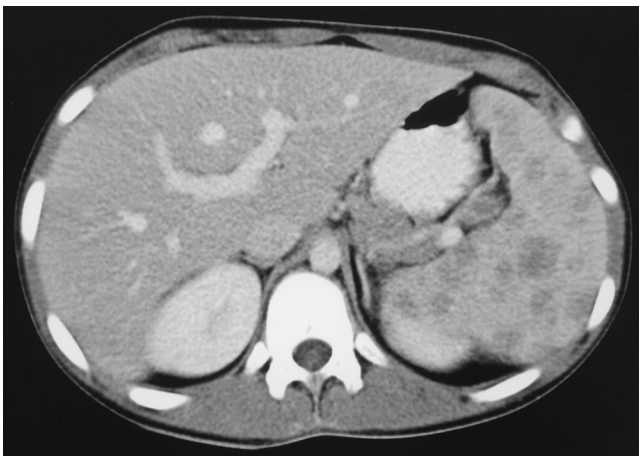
Abdominal computed tomographic scan of a 15-year-old with fever, weight loss, and orthopnea. The diagnosis was Hodgkin disease. The spleen shows hypoechoic lesions, typical of lymphoma.
